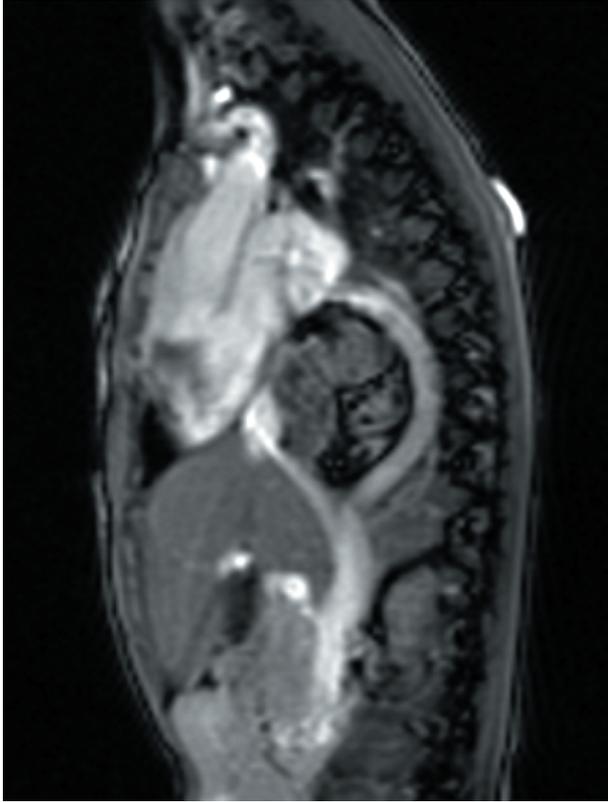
Retrocardiac diaphragmatic hernia. Thoracoabdominal CT-scan sagittal cut at 2 years and 9 months of age.
